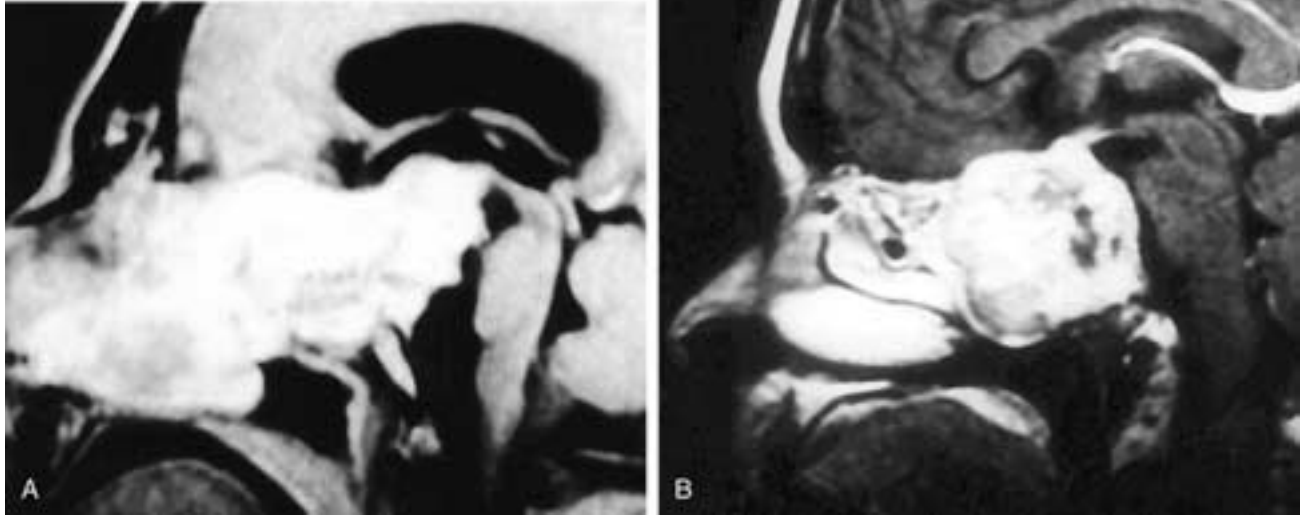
Sagittal T1-weighted, contrast-enhanced MR image (A) shows a large, enhancing mass that replaces almost the entire clivus and extends forward to fill the sinusal cavities. There is also a large dorsal extension of this tumor. This is an unusually large chordoma with uncharacteristic exuberant ventral and dorsal growth. Sagittal T1-weighted, contrast-enhanced MR image (B) shows a bulky, nonhomogeneously enhancing mass in the clivus and sphenoid sinus. This is a more characteristic MR appearance of a chordoma than that shown in A.
